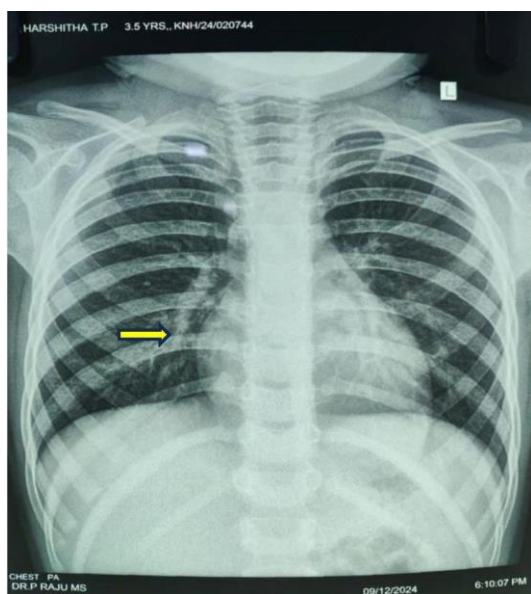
Chest X-ray of a 4-year-old female child with increased broncho-vascular markings on the right.
